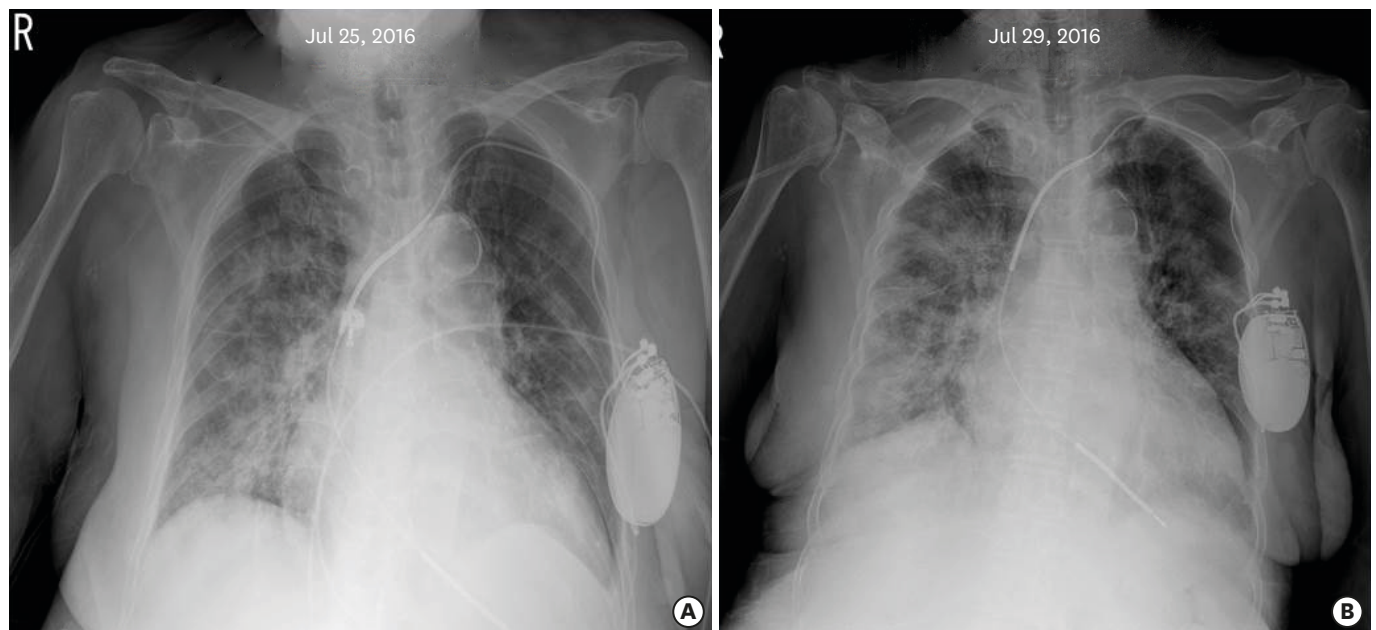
Chest X-ray on admission (A) and 4 days after intensive diuretic therapy (B). Despite intensive diuretic therapy, pulmonary vascular markings and consolidation did not improve.
